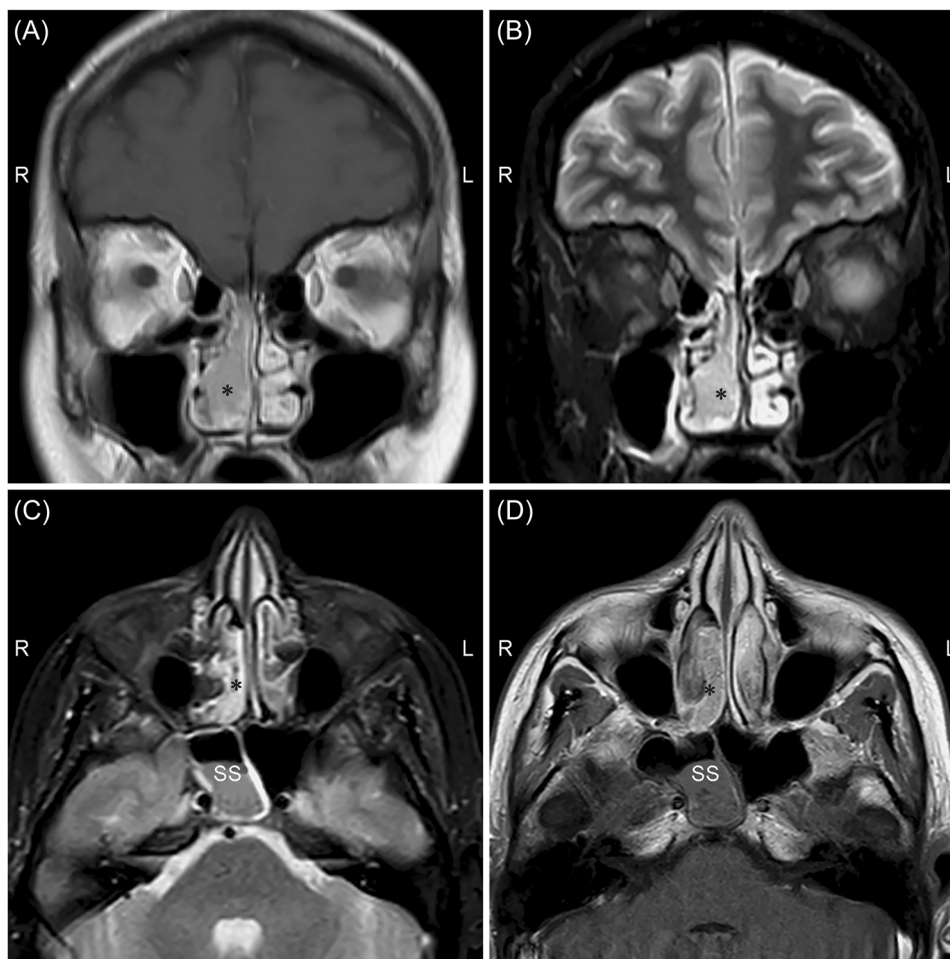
Preoperative contrast-enhanced T1-weighted magnetic resonance imaging (MRI) in coronal (A) and axial (C) view showing a hyperintense neformation of right ethmoid and nasal fossa with contrast enhancement. The black asterisk points out the neformation. Preoperative coronal (B) and axial (D) MRI showing a T2-hypointense signal of the ethmoidal neformation and the T2-hyperintense inflammatory signal in right sphenoidal sinus (SS).
